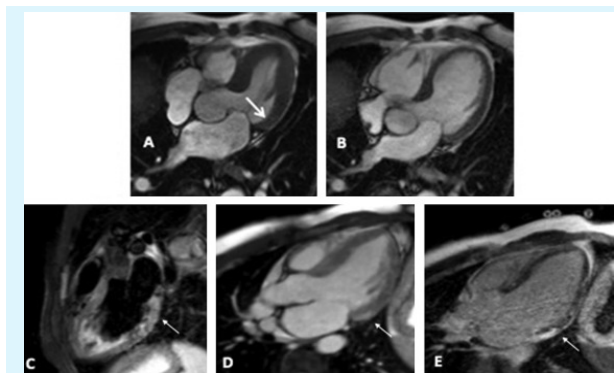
MRI examination phases and Lake Louise diagnostic criteria of acute myocarditis in a 21-year-old patient presenting with an “ACS-like” clinical syndrome.
